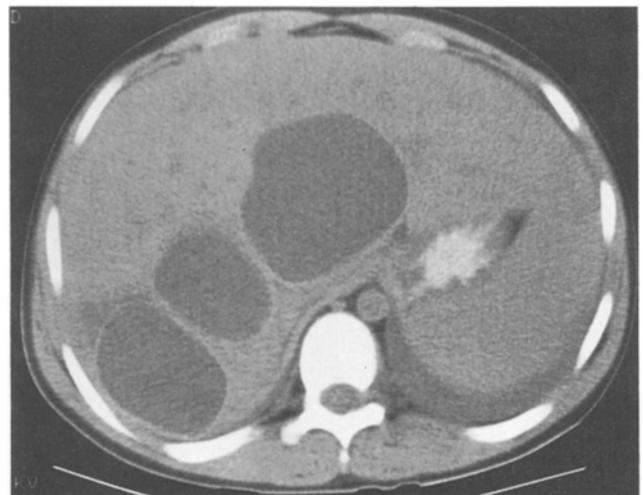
Case 1. Contrast-enhanced CT shows 3 cysts with high-attenuation walls.
